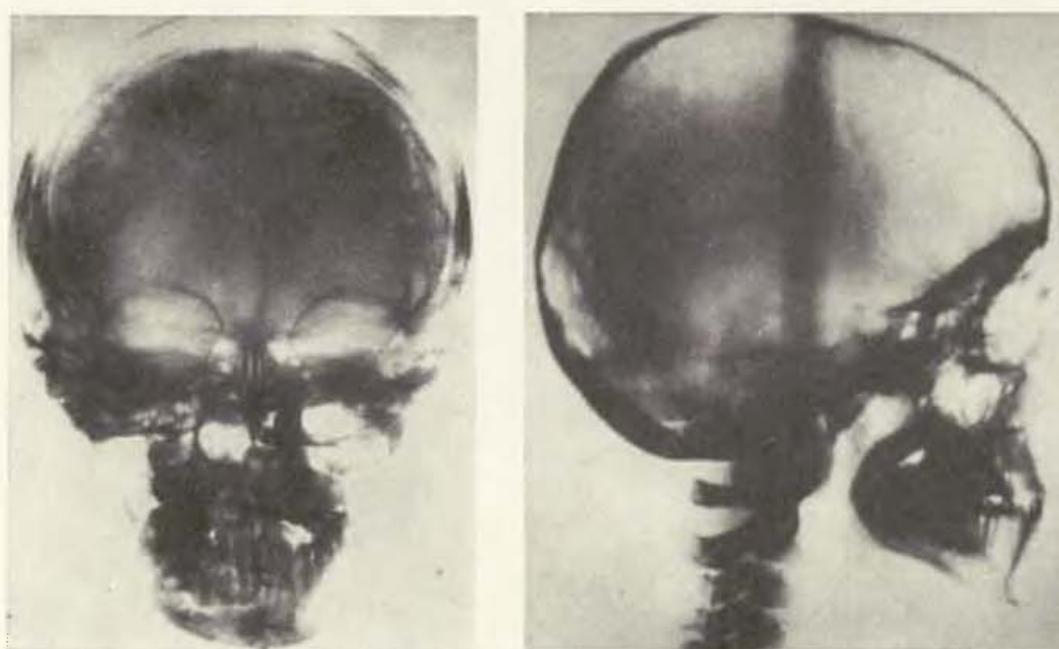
X-rays B.T. to show maxillae after excision of vomer.
